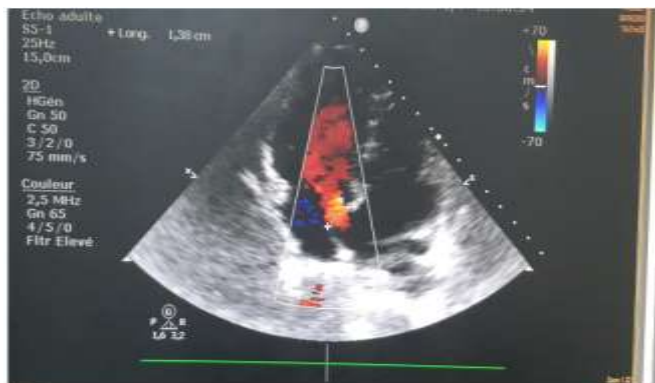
TTE with color Doppler showing the atrial septal defect.
